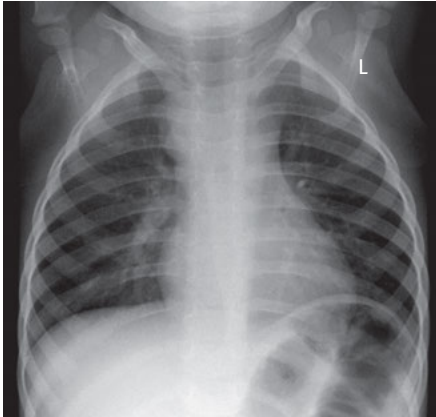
Chest X-ray of a 1.5-year-old girl with a bronchogenic cyst projecting from the mediastinum. The typically rounded paratracheal mass with uniform density was found incidentally, and the girl was asymptomatic.
